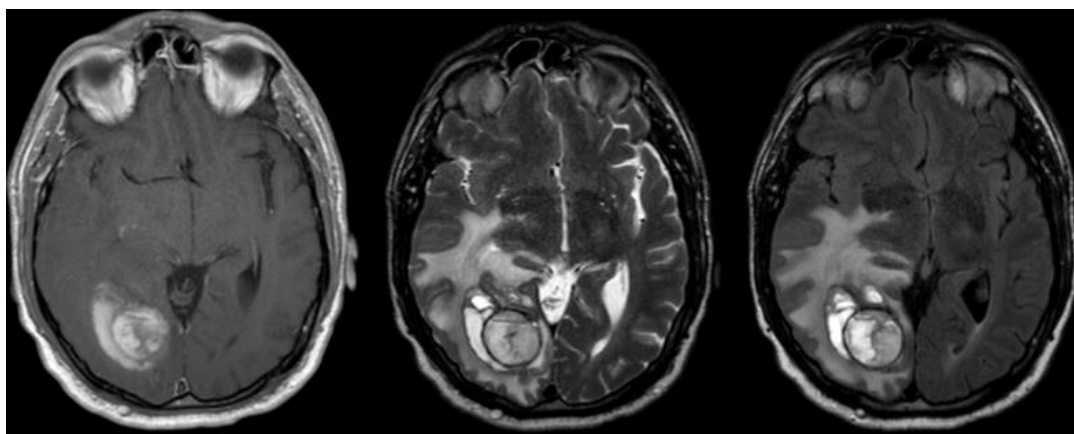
T1, T2, FLAIR MRI scans in GBM
